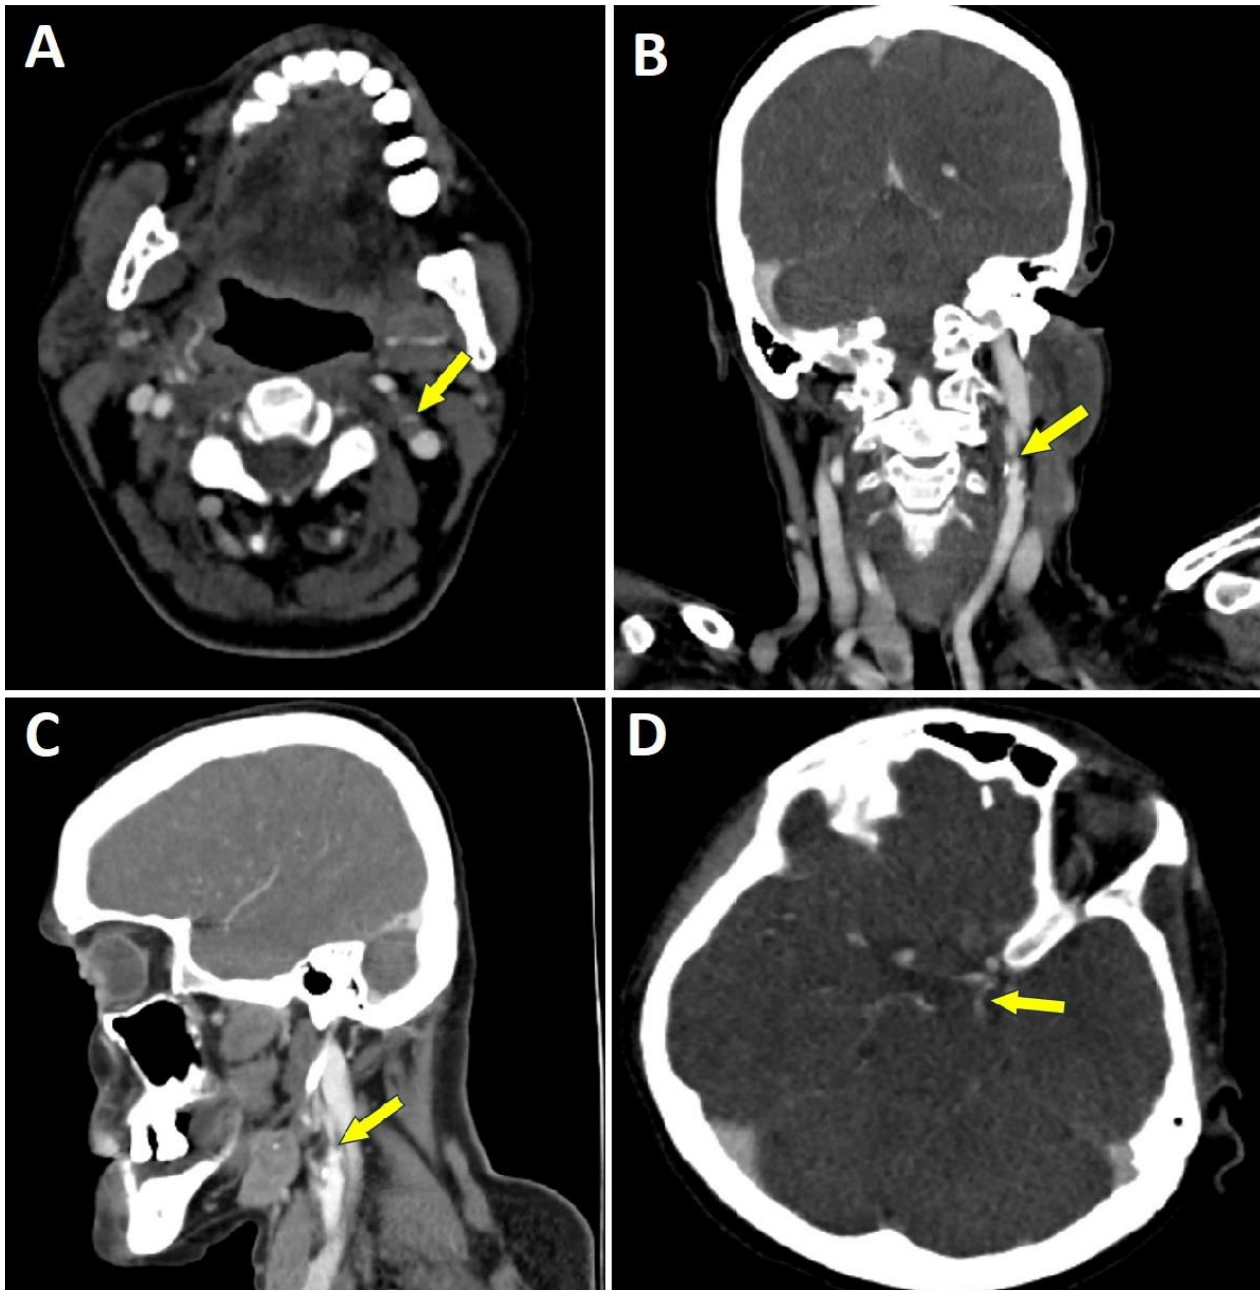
In cervical CT angiography, over 90% stenosis was observed at the bulbous in the proximal left ICA cervical segment in A) axial section, B) coronal section, C) sagittal section, and D) Left fPCA was observed in the axial section in cranial CT angiography.
